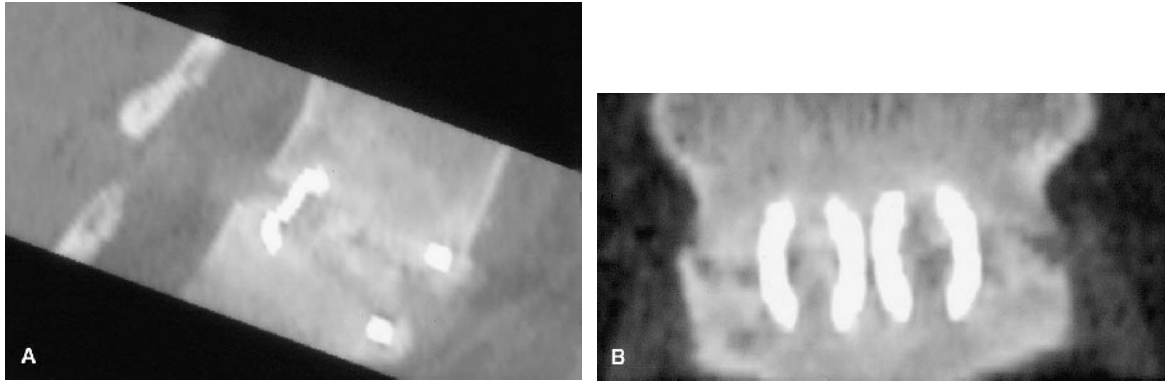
At 24 months after surgery, thin-cut CT scans were repeated. A. Sagittal reconstruction 24 months after surgery through the midportion of the LT-CAGE shows abundant new bone formation throughout the central portion of the cage. B. Coronal reconstructions shows new bone formation through the cages and lateral to the cages. This new bone formation connects the adjacent vertebral endplates.
